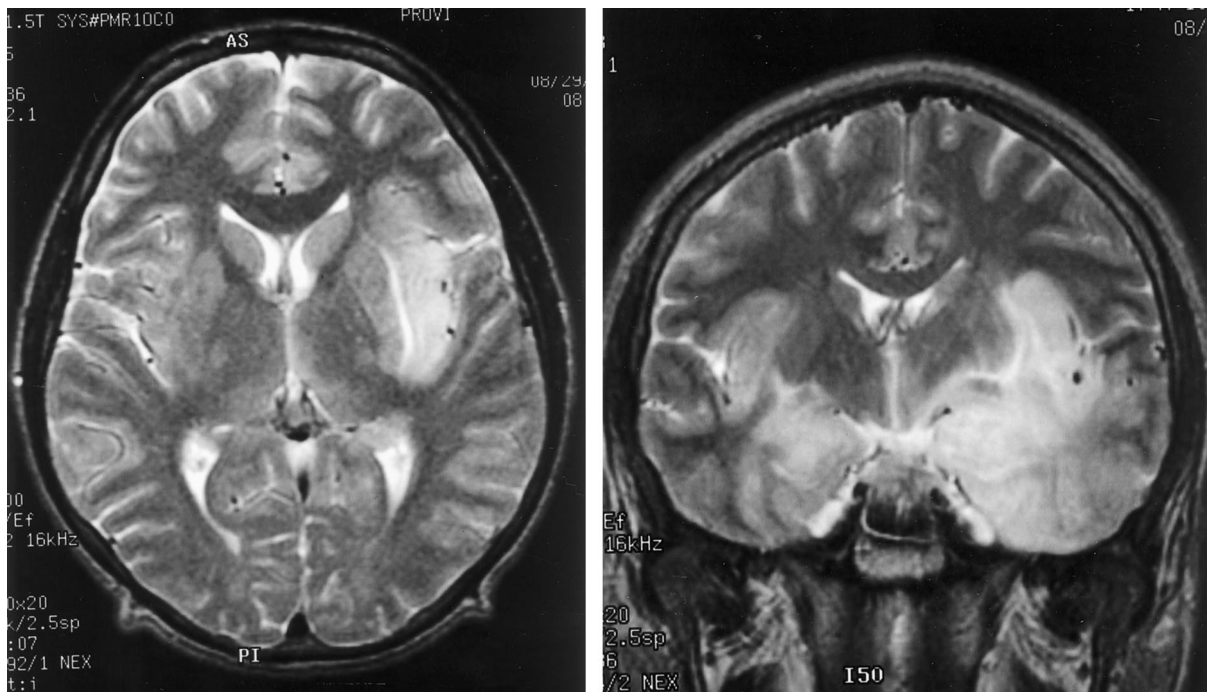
Magnetic resonance image of brain showing mild mass effect from abnormalities in the left medial temporal lobe, left insular cortex, and subcortical white matter that do not enhance with gadolinium. These findings are characteristic of early herpes simplex virus encephalitis.
